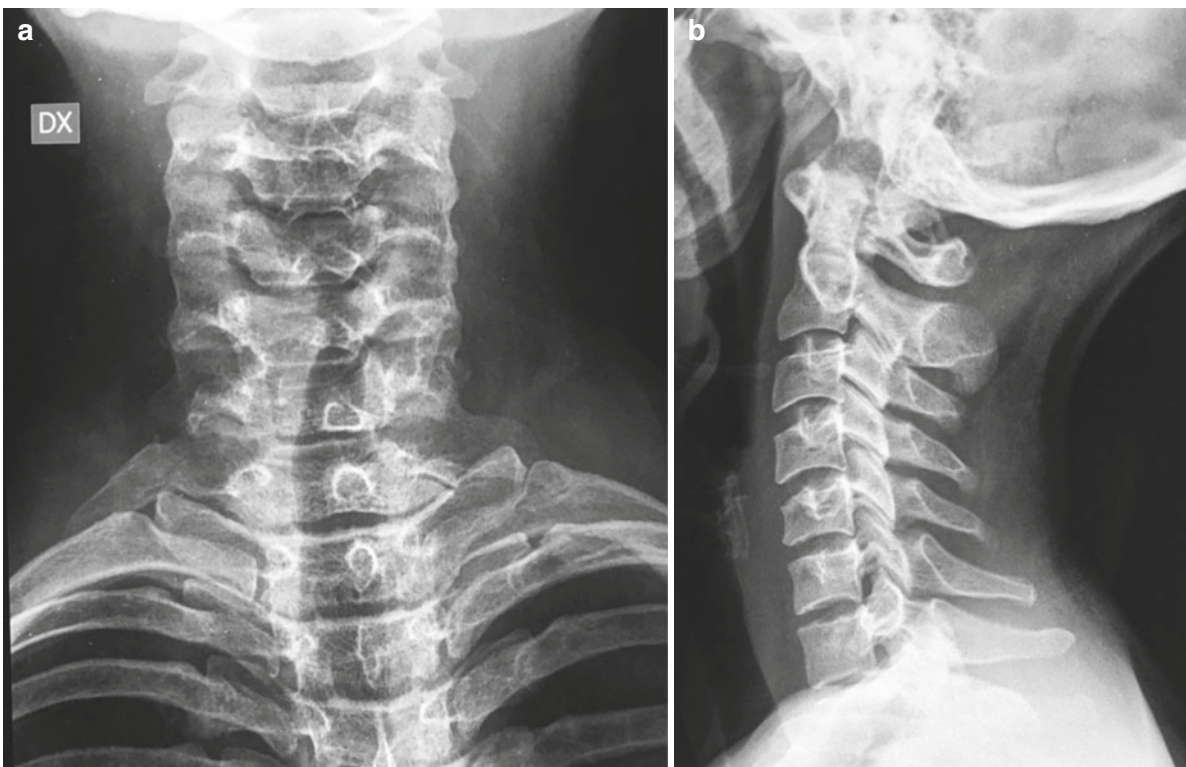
X-ray of the cervical spine in antero-posterior (a) and lateral (b) views showing the presence of a supernumerary C7 vertebra
